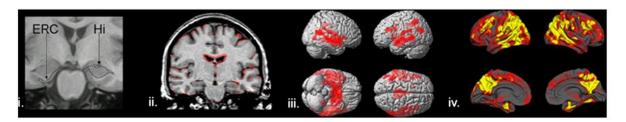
Volumetric MRI in the detection and tracking of AD, including (i) accelerated rates of atrophy in the hippocampus (Hi) and entorhinal cortex (ERC) regions-of-interest (Mike Weiner, with permission); (ii) accelerated rates of whole brain atrophy using sequential MRIs, as shown in red in a symptomatic AD patient (Nick Fox, with permission); (iii) regional gray matter loss, as shown in this statistical brain map comparing symptomatic AD patients and controls; and (iv) regional thinning in cerebral cortex comparing symptomatic AD patients and controls.
